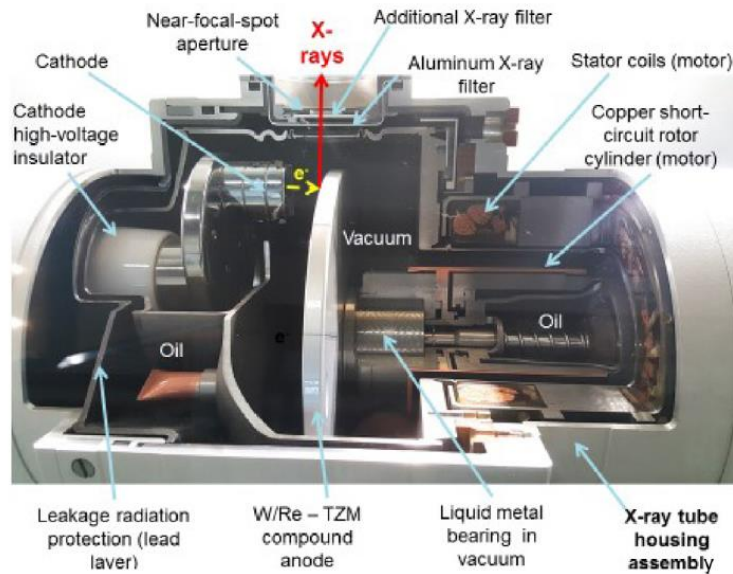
Cut view of an X-ray tube assembly
